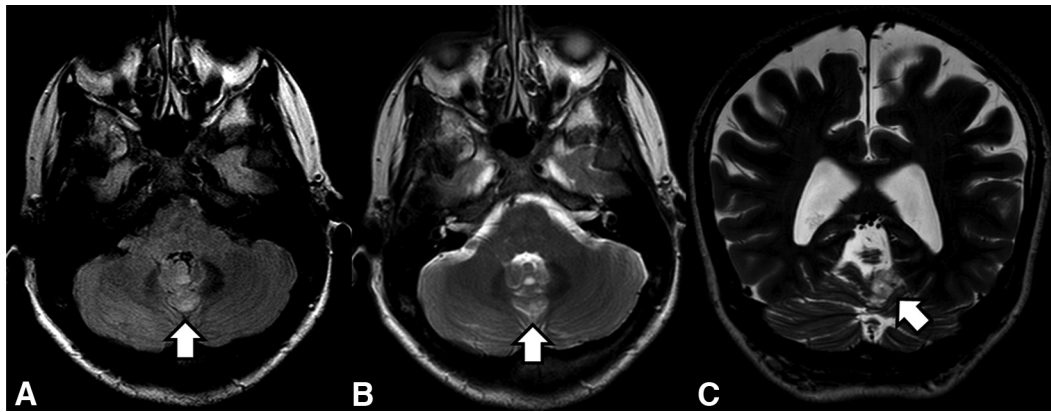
RGNT. Axial FLAIR (A), axial T2WI (B), and coronal T2WI (C) show a solid tumor in the cerebellar vermis/floor of the fourth ventricle with hyperintensity on FLAIR imaging (arrow in A) and T2WI (arrows in B and C), as well as no significant enhancement (not shown).
